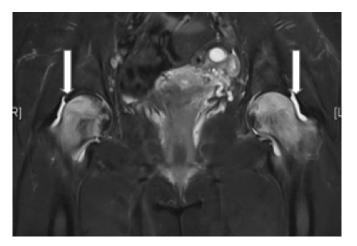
27 year-old woman, MR image showing that migratory osteoporosis.
